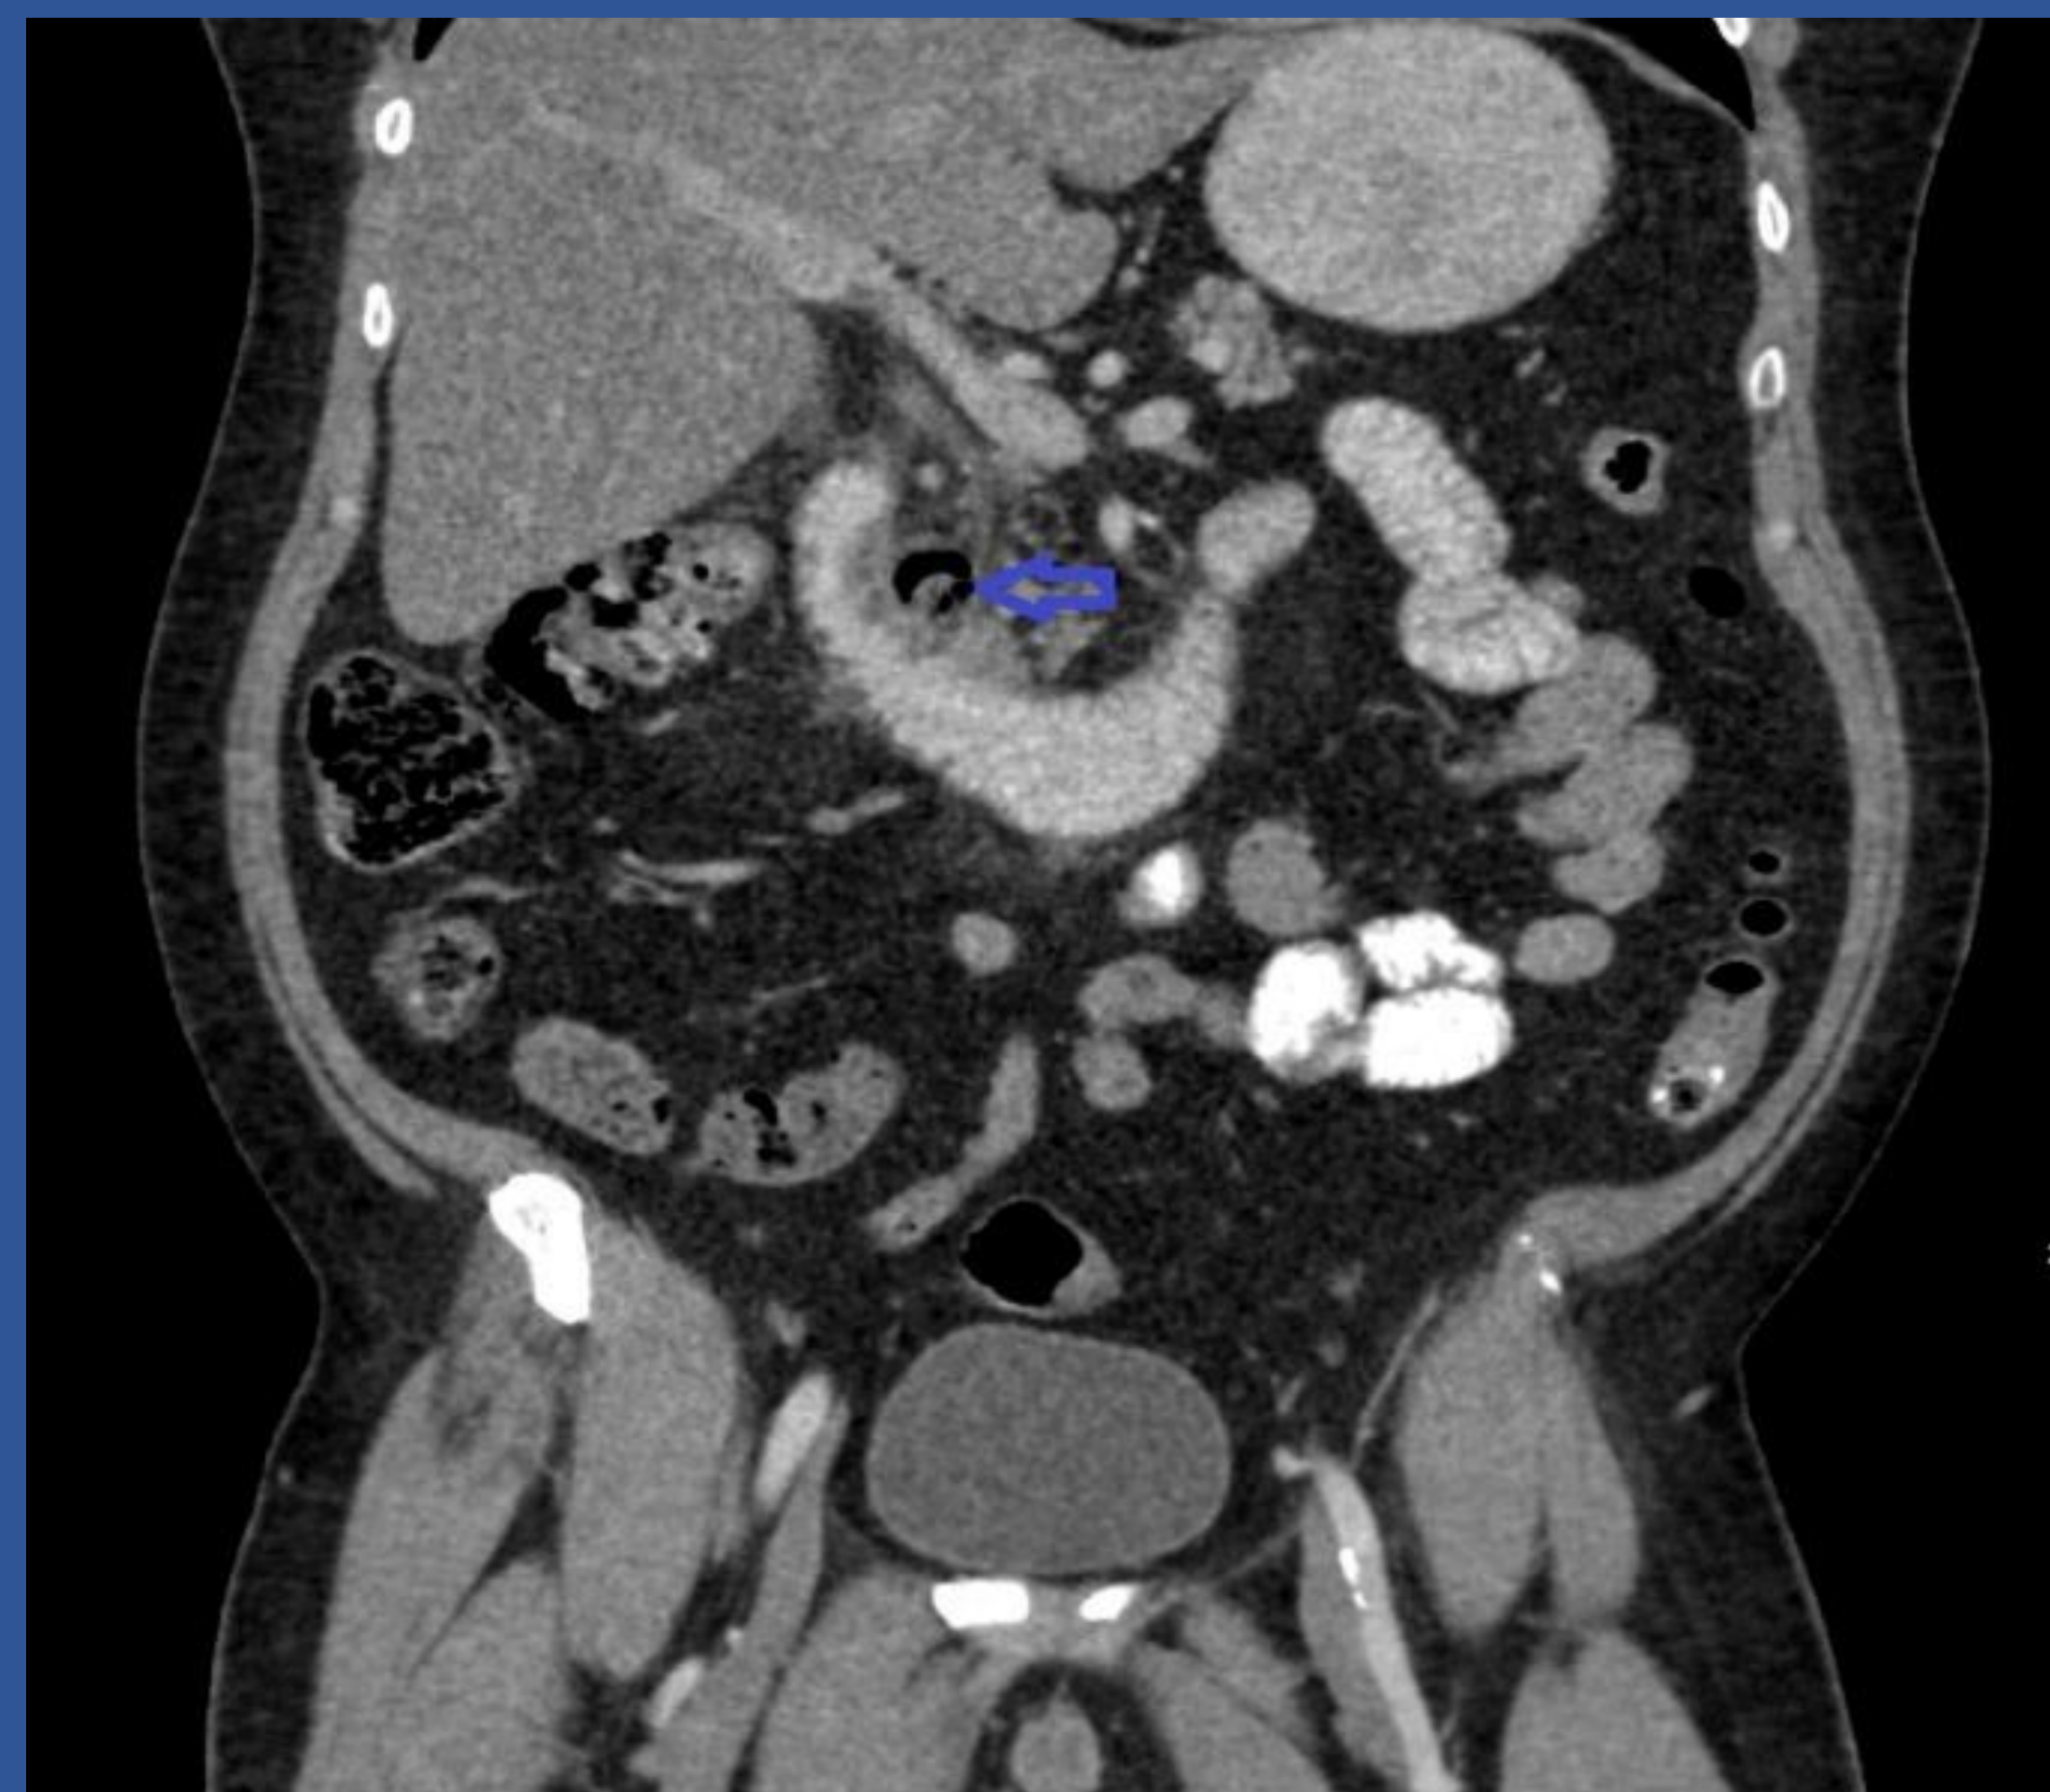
CT abdomen and pelvis showing inflammatory changes within the second portion of the duodenum adjacent to a duodenal diverticulum.
